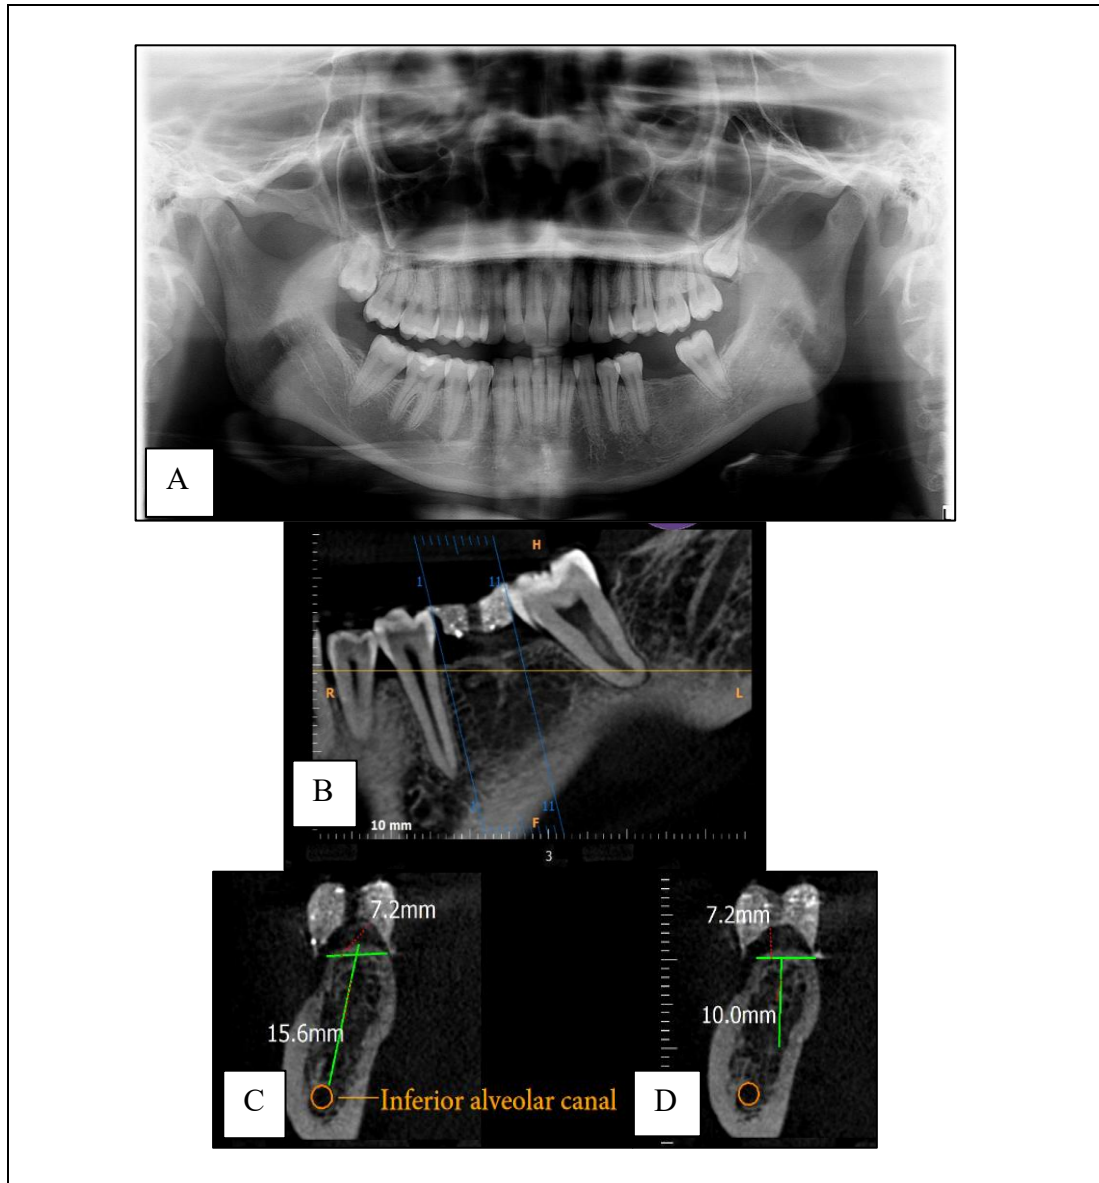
Radiographic Assessment of the Patient Before Including or Excluding, Either of the Patients in this Study.
